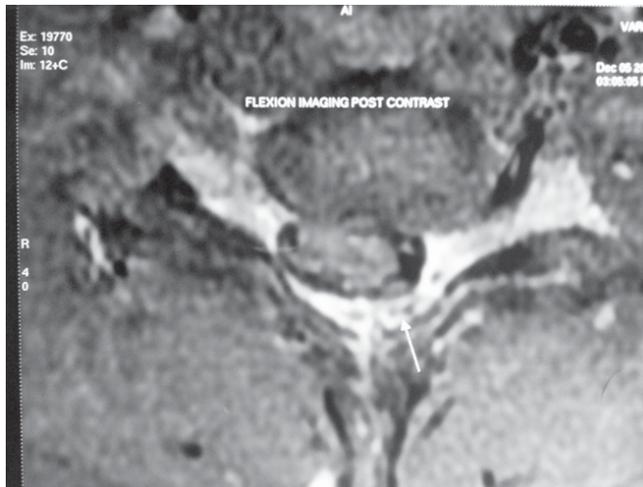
Showing Posterior Epidural Mass in MRI
